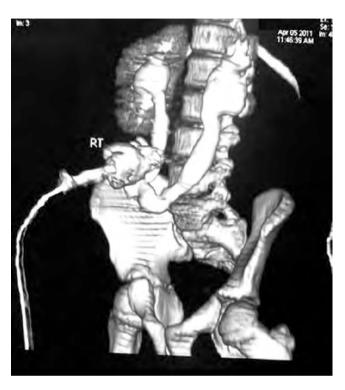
CT scan of a sacral agencies patient with ileal conduit (neurogenic bladder with renal failure who improved in 3 years after diversion)
